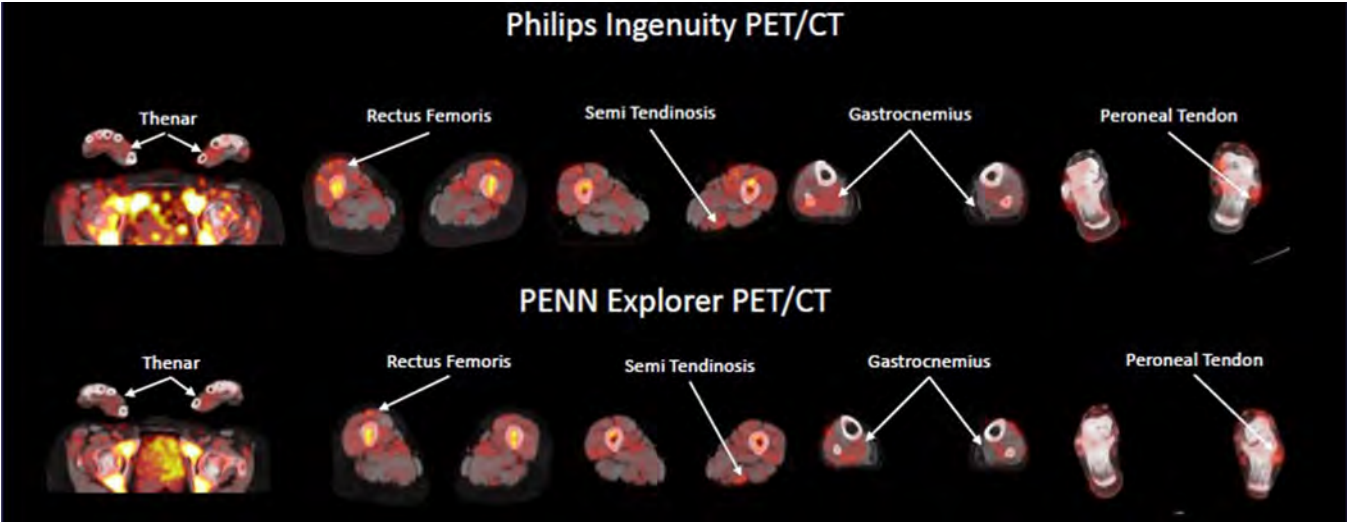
Representative PET/CT images from subject 4 demonstrating 89Zr-Df-IAB22M2C signal in the hands, anterior thigh and gastrocnemius muscles.
